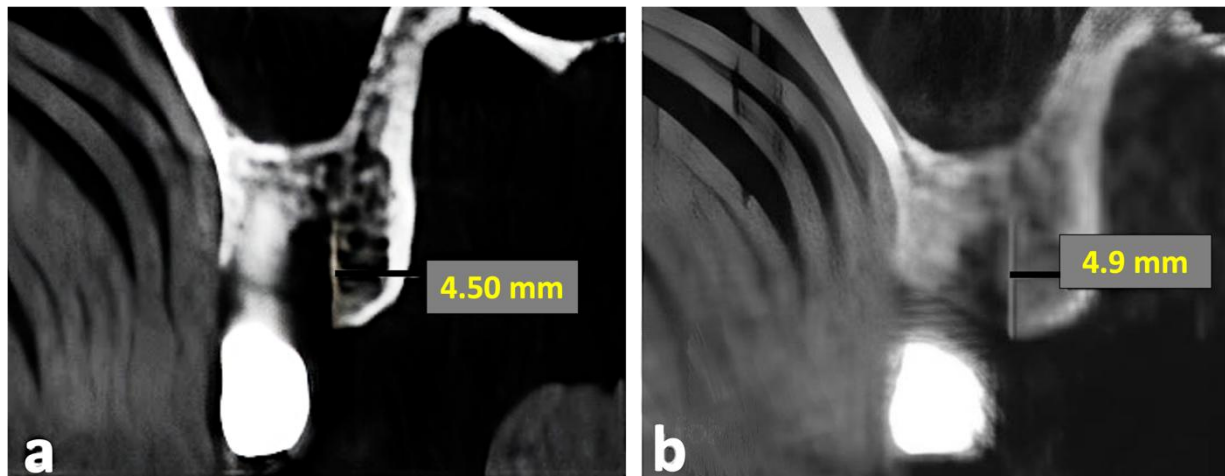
Measurements of an infra-bony defect (a). High-resolution CBCT (b). Standard resolution CBCT on coronal views.
